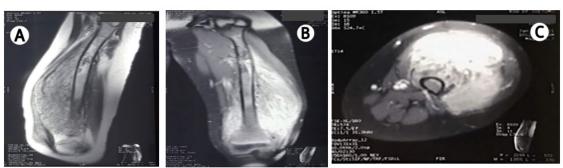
Femoral MRI of Ms. Az. (A) Sagittal view. (B) Coronal view. (C) Axial view at the level of middle third
